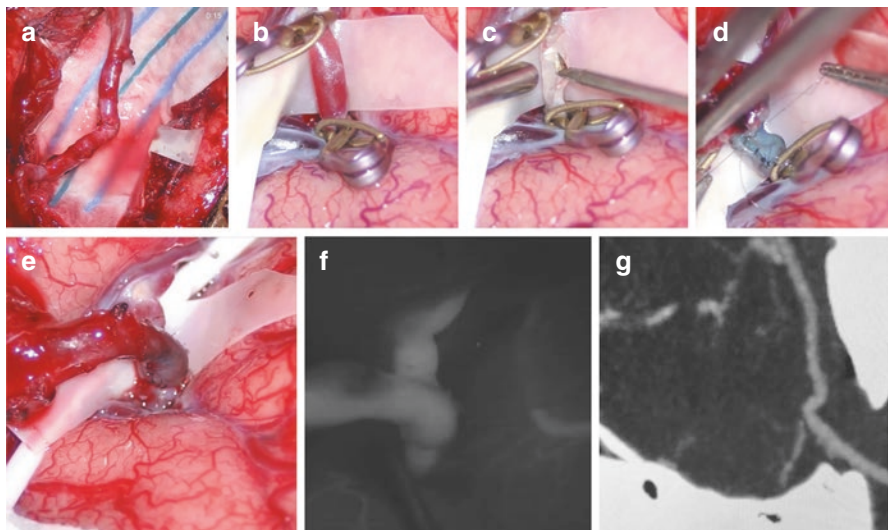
STA-MCA bypass (a–g). (a) Dissected STA, (b) Dissected and clamped MCA branch, (c) arteriotomy of the recipient vessel, (d) Suturing the anastomosis between STA and the MCA branch using 10-0 Nylon, (e) Flowing bypass, (f) Indocyanine Green fluorescent showing patent bypass, (g) CTA reconstruction showing filling of the MCA via the bypass
